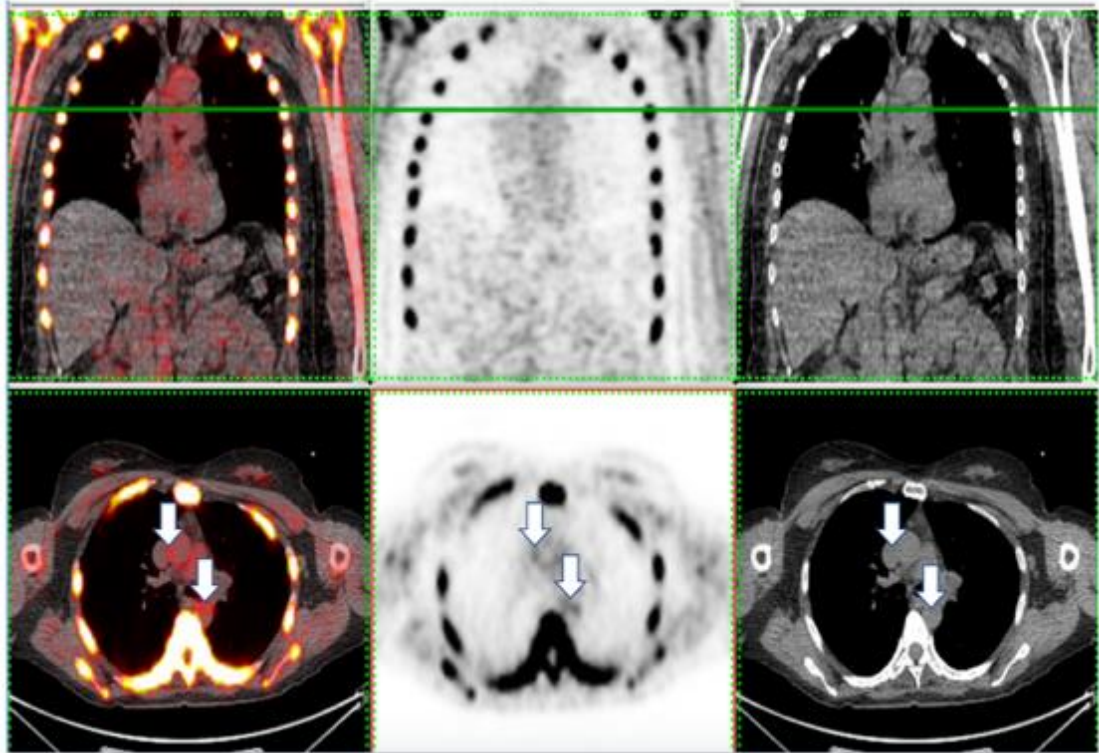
^{18}F -NaF PET/CT image of the heart for a 44 year old, female AKU patient, showing high background activity in soft tissues, specifically in the heart region.
